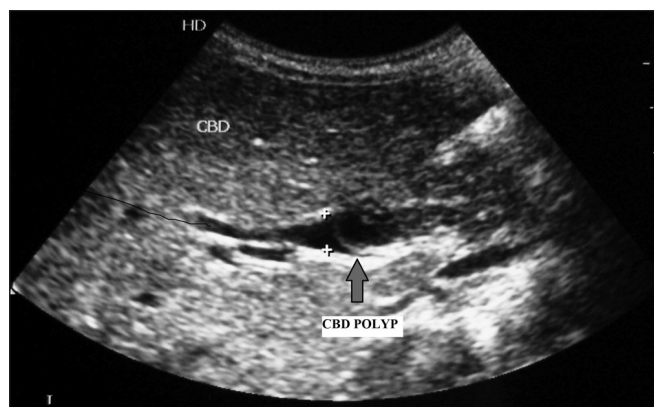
Ultrasound showing filling defect in the lower common bile duct (CBD) polyp
